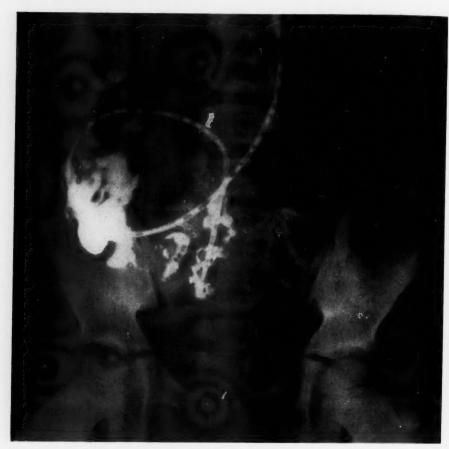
Roentgenogram showing the lipiodal visualization of the umbilical sinus.
